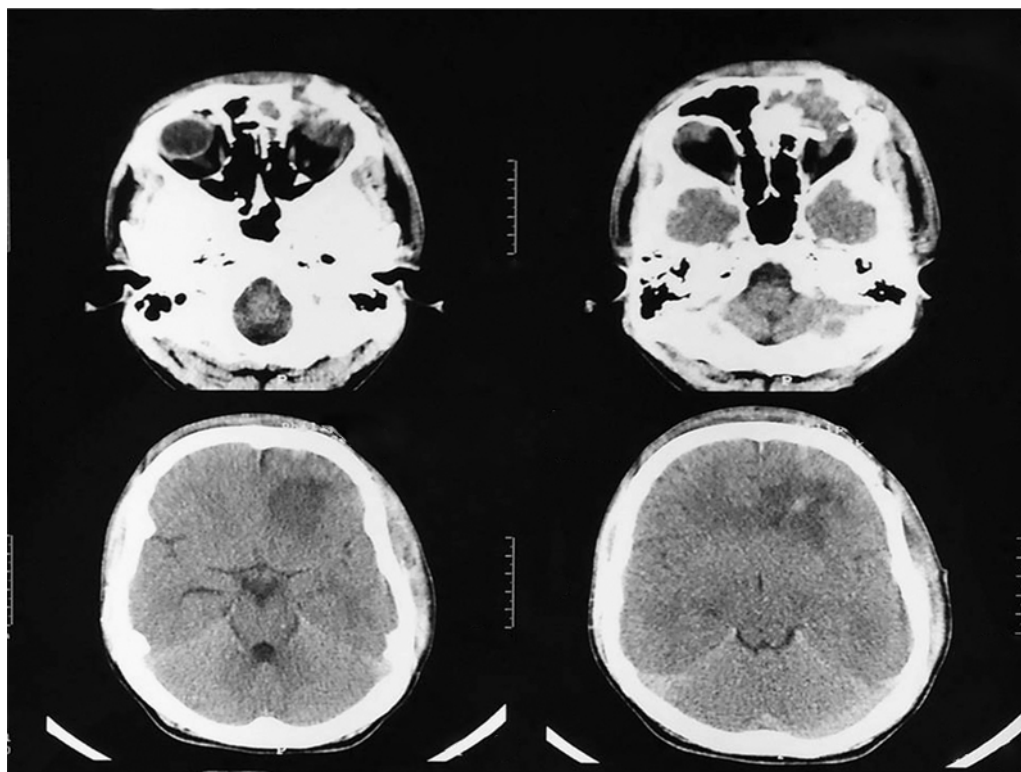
Plain computed tomographic head demonstrating oedema around the penetrating object. Note, however, that the organic object trajectory cannot be well delineated.
